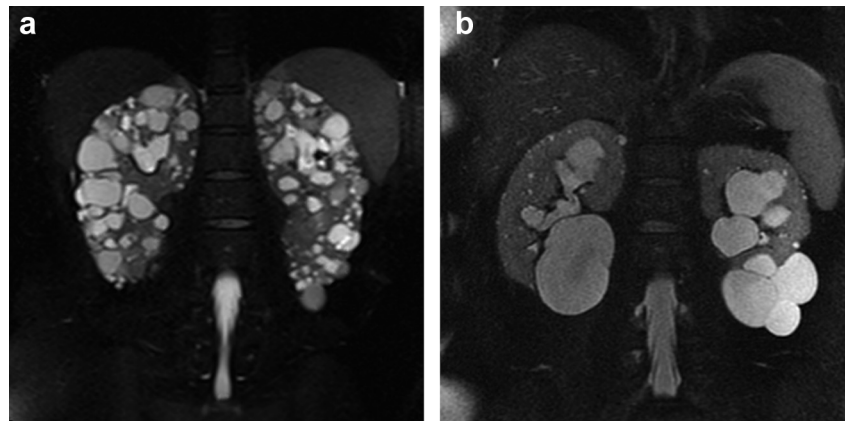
Exemplary MR images of class 1 and 2. (a) Class 1 example showing cysts of small to medium sizes distributed through parenchyma in bilateral kidneys, and (b) class 2 example showing a large dominant exophytic cyst in both kidneys and relatively asymmetric distribution of cysts in bilateral kidneys. MR, magnetic resonance.
